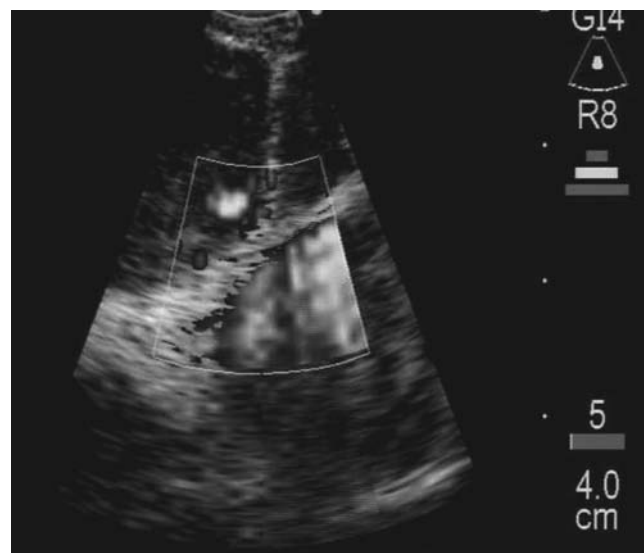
Typical linear probe endobronchial ultrasound-guided transbronchial needle aspiration image (prior to sampling) of lymph node demonstrating intra-nodal vessels and adjacent aorta (in power Doppler mode). Reproduced with permission from BMJ Publishing Group Ltd.⁴
